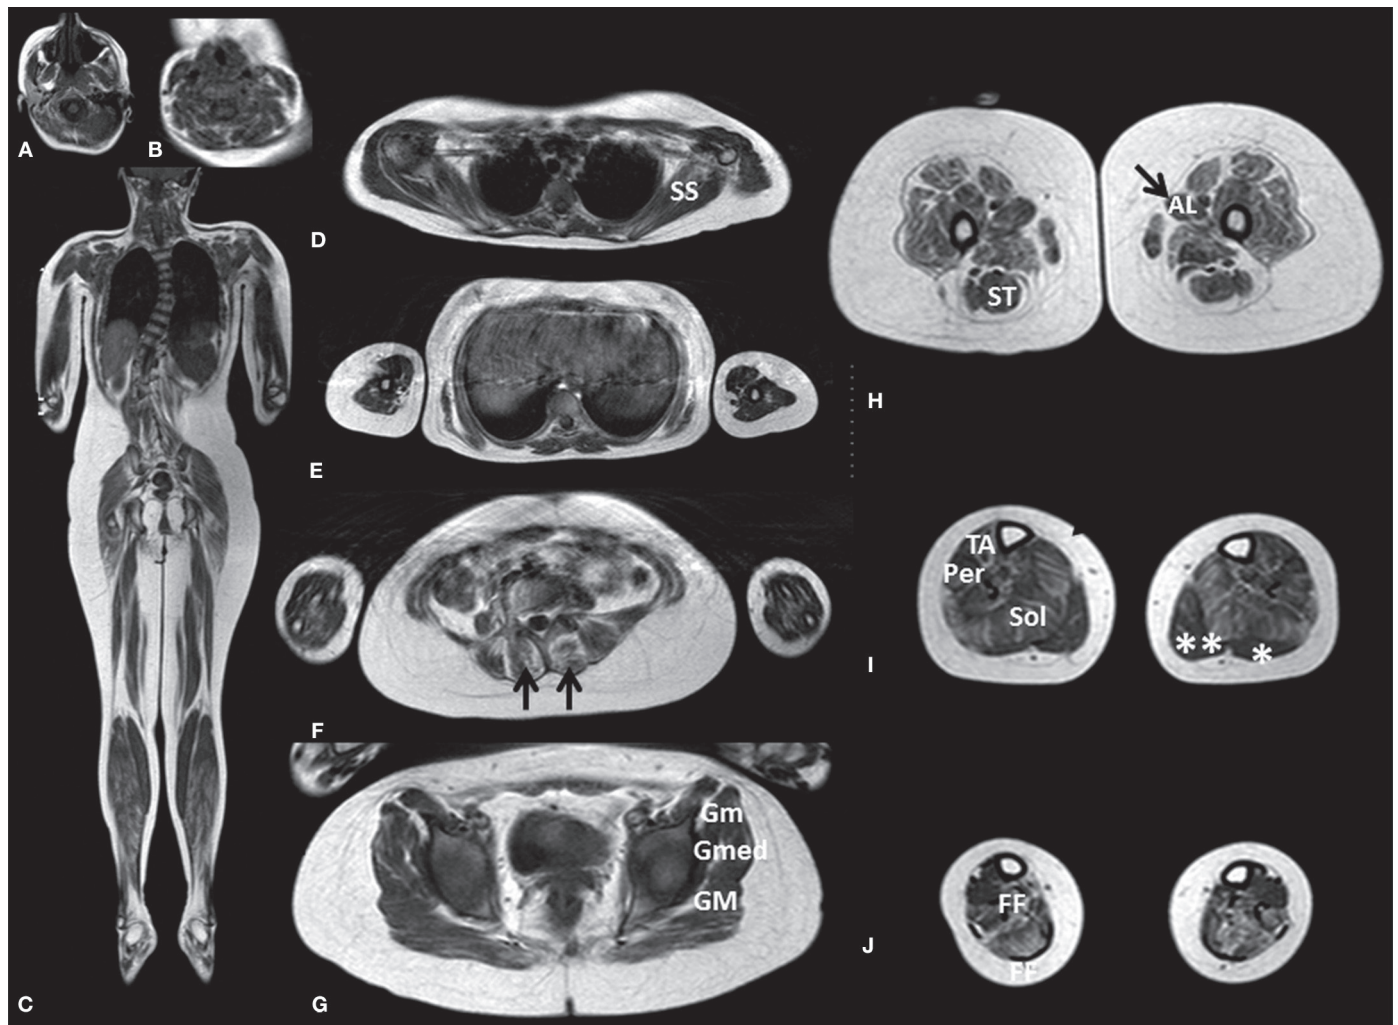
T1 weighted Whole-Body Magnetic Resonance Imaging (WB-MRI) findings in an ambulant 13-year-old SMA3b girl. Frontal (C) and coronal views (A-B, D-J) Regional analysis: Fibroadipous replacement (hyperintense signal) is more predominant in lower limbs (H-J), pelvic girdle (G), thigh (H) and lumbar paraspinals (black arrows in E).
